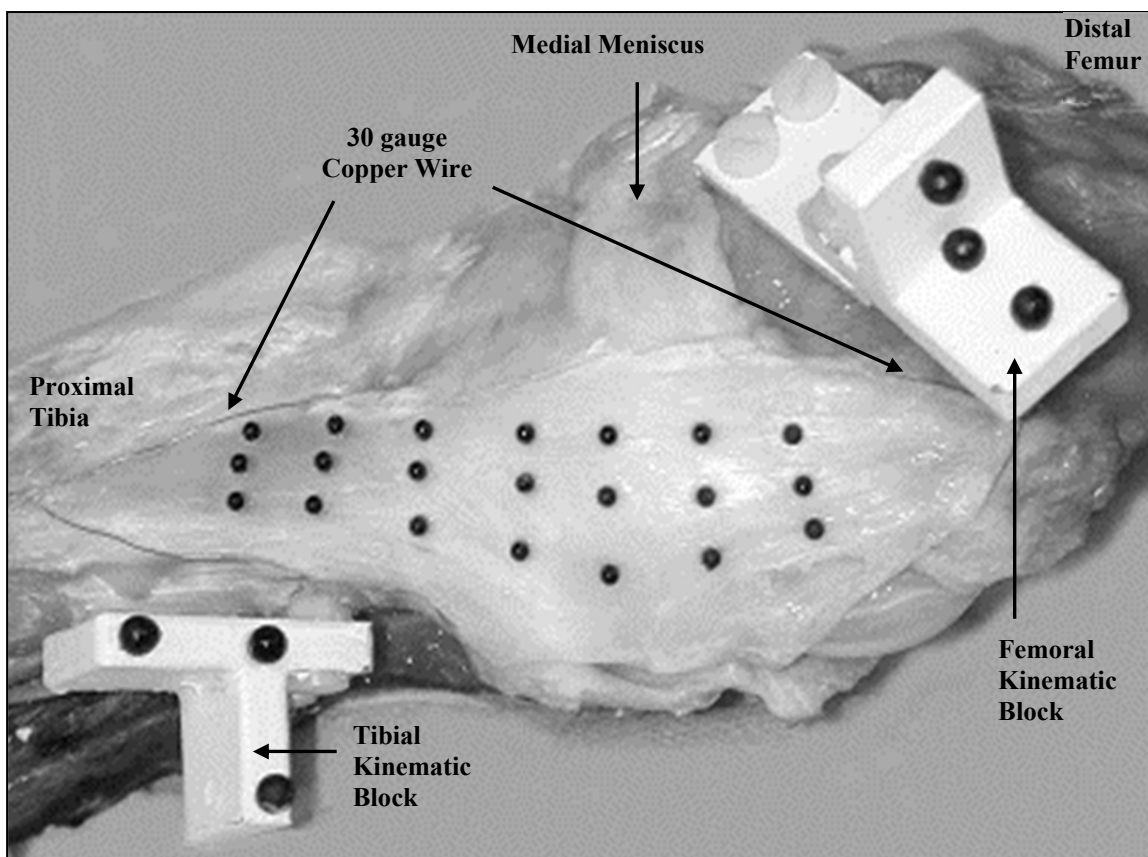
Photograph of test setup for simultaneous measurement of MCL strain and knee joint kinematics. Twenty-one markers (2.38 mm dia.) defined 18 regions for strain measurement. Kinematic blocks were used to measure tibiofemoral kinematics during testing. Femoral and tibial kinematic blocks, each with three contrast markers (4.75 mm dia), were affixed to the cortical bone. The kinematic blocks were used to measure tibiofemoral kinematics and to register the CT data with the configuration of the knee during experimental testing. Insertion sites were marked with 30 gauge copper wire.
